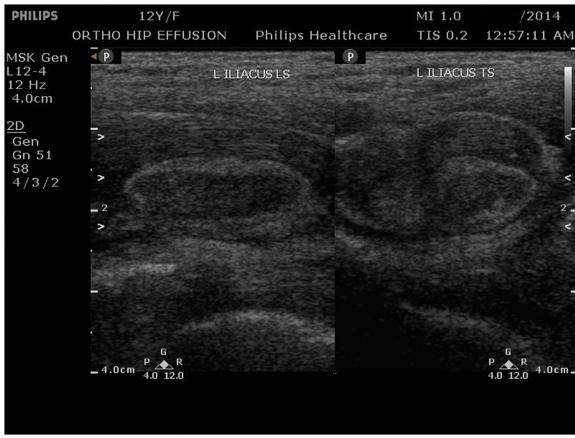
Ultrasonography of the left hip showing a heterogeneous hypoechoic collection in the iliopsoas muscle in the region of the iliac bone, measuring 2 cm in maximum thickness.
